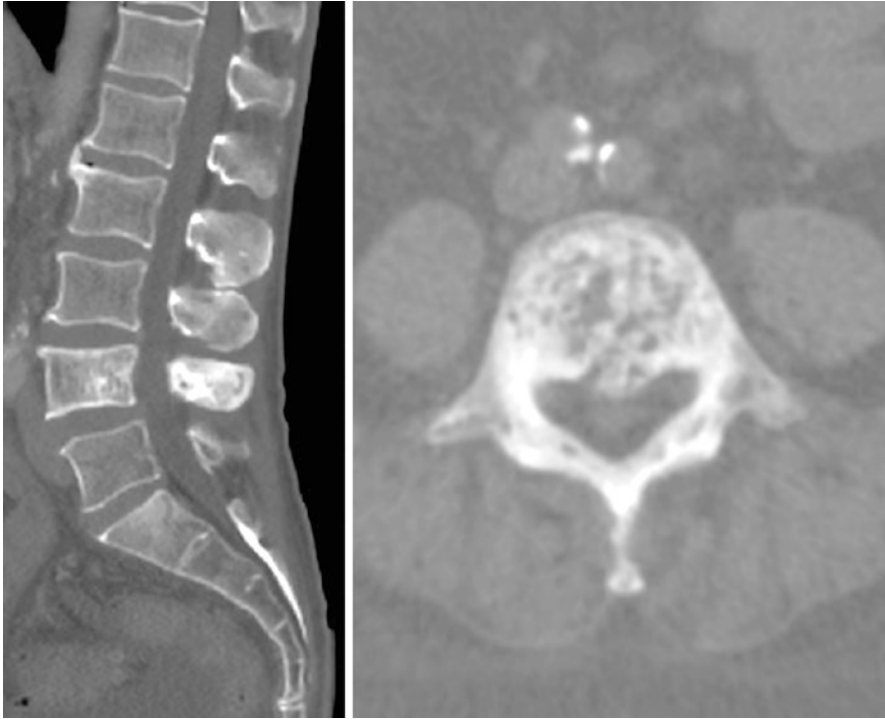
Sagittal and axial CT images showing sclerotic bone formation at L4 during the third phase of Paget's disease
